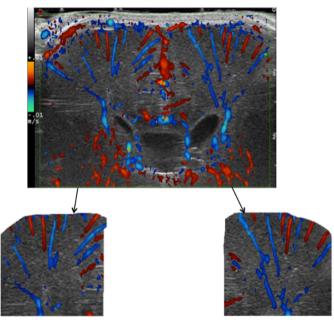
Top image: Cranial ultrasound image including colour Doppler. Coronal view at level of Monro, with 13 Mhz probe showing both hemispheres with microvessels in the periventricular white matter. Below left: region of interest: periventricular white matter right hemisphere Below
